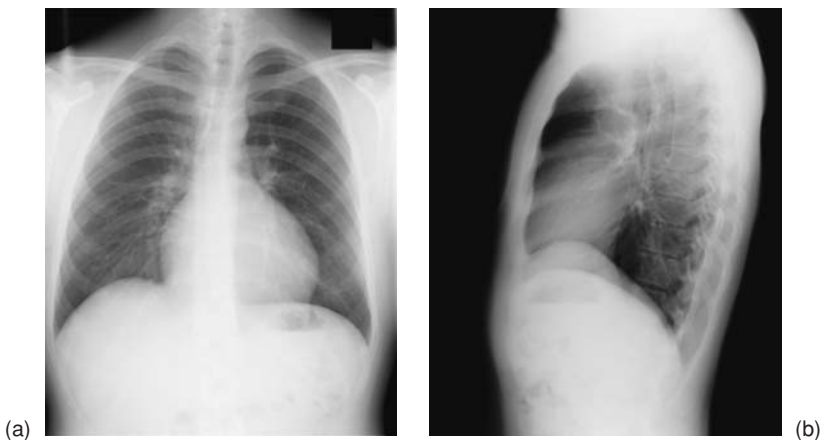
Preoperative chest radiograph from the patient presented. Note enlargement of the cardiac silhouette and a narrow pedicle on the posteroanterior view (a). The lateral chest radiograph (b) demonstrates loss of retrosternal air space consistent with right heart enlargement.
